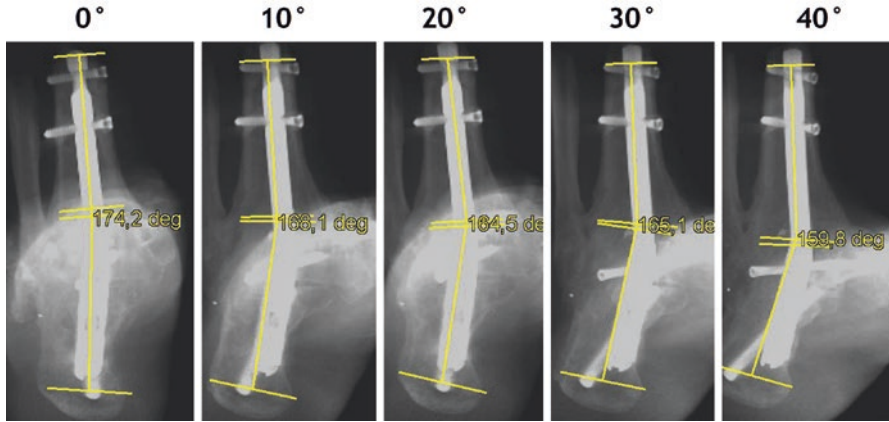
Conventional radiographs for measurement of hindfoot alignment in a patient with healed tibio-talo-calcaneal arthrodesis with retrograde nail. The healed arthrodesis ensures uniform hindfoot position during repetitive radiographic assessment. Radiographs with different internal rotations (0–40°) of the foot in relation to the central beam were obtained, and the hindfoot angle is measured. The measured hindfoot angles ranged from 5.8° to 21.2°. The different angles are not influenced by the “real” hindfoot angle (healed arthrodesis plus nail) but only by different orientation (internal rotation) of the foot and ankle during radiographic assessment
